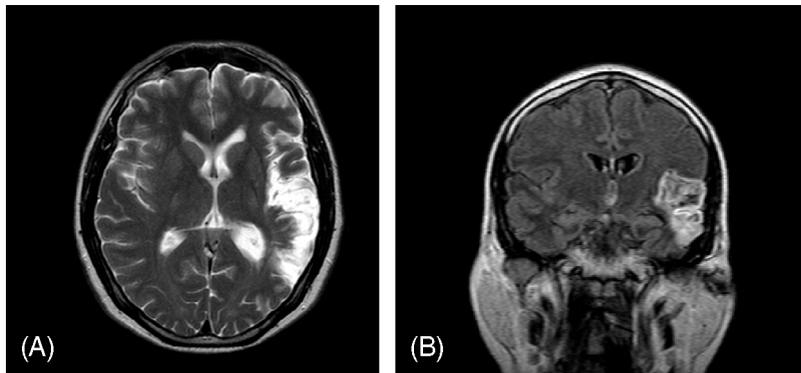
MRI scan of a 42-year-old patient with no known risk factors for stroke presenting with Wernicke’s aphasia and mild right hemiparesis and hemihypoesthesia, involving predominantly the face and arm (A). Note the involvement of the lateral part of the temporal lobe on the coronal sequence (B).
